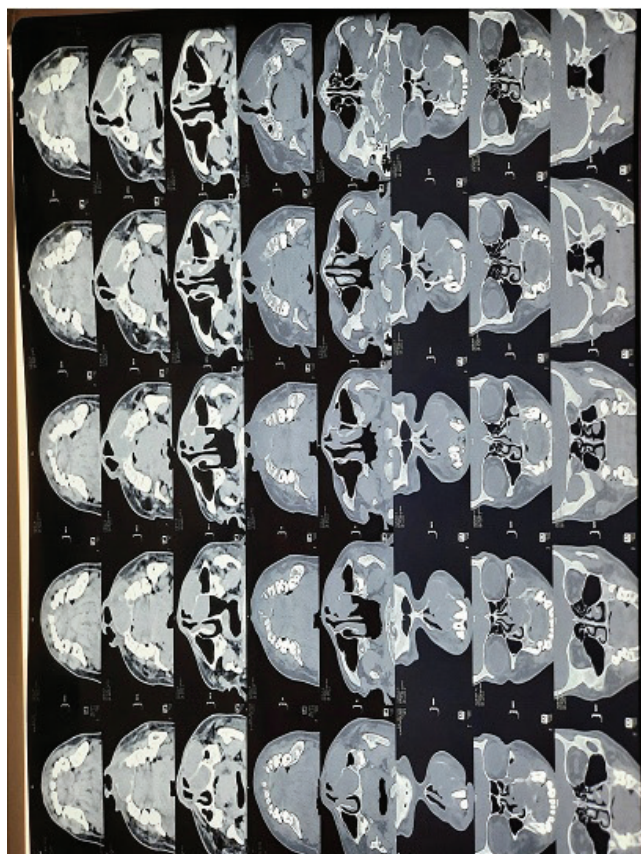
Axial and coronal section of CT scan
